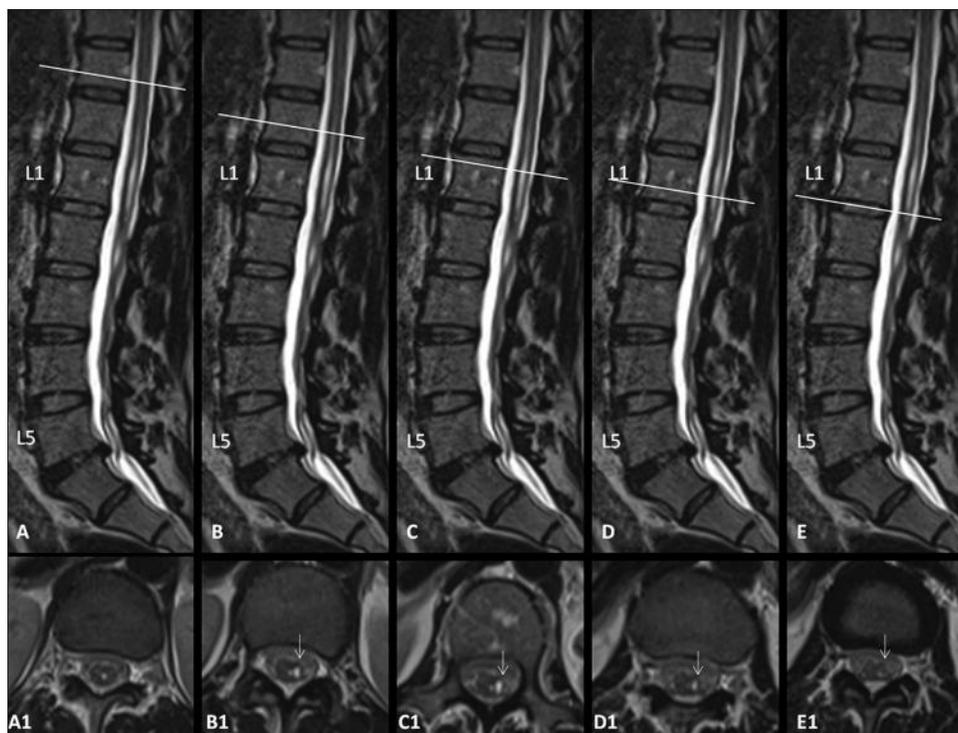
(A-E) Sagittal T2 images of thoracolumbar spine of patient 2. (A1-E1) Serial axial T2-weighted images at the level of lower spinal cord and conus showing slit-like T2 hyperintensity within left hemicord
